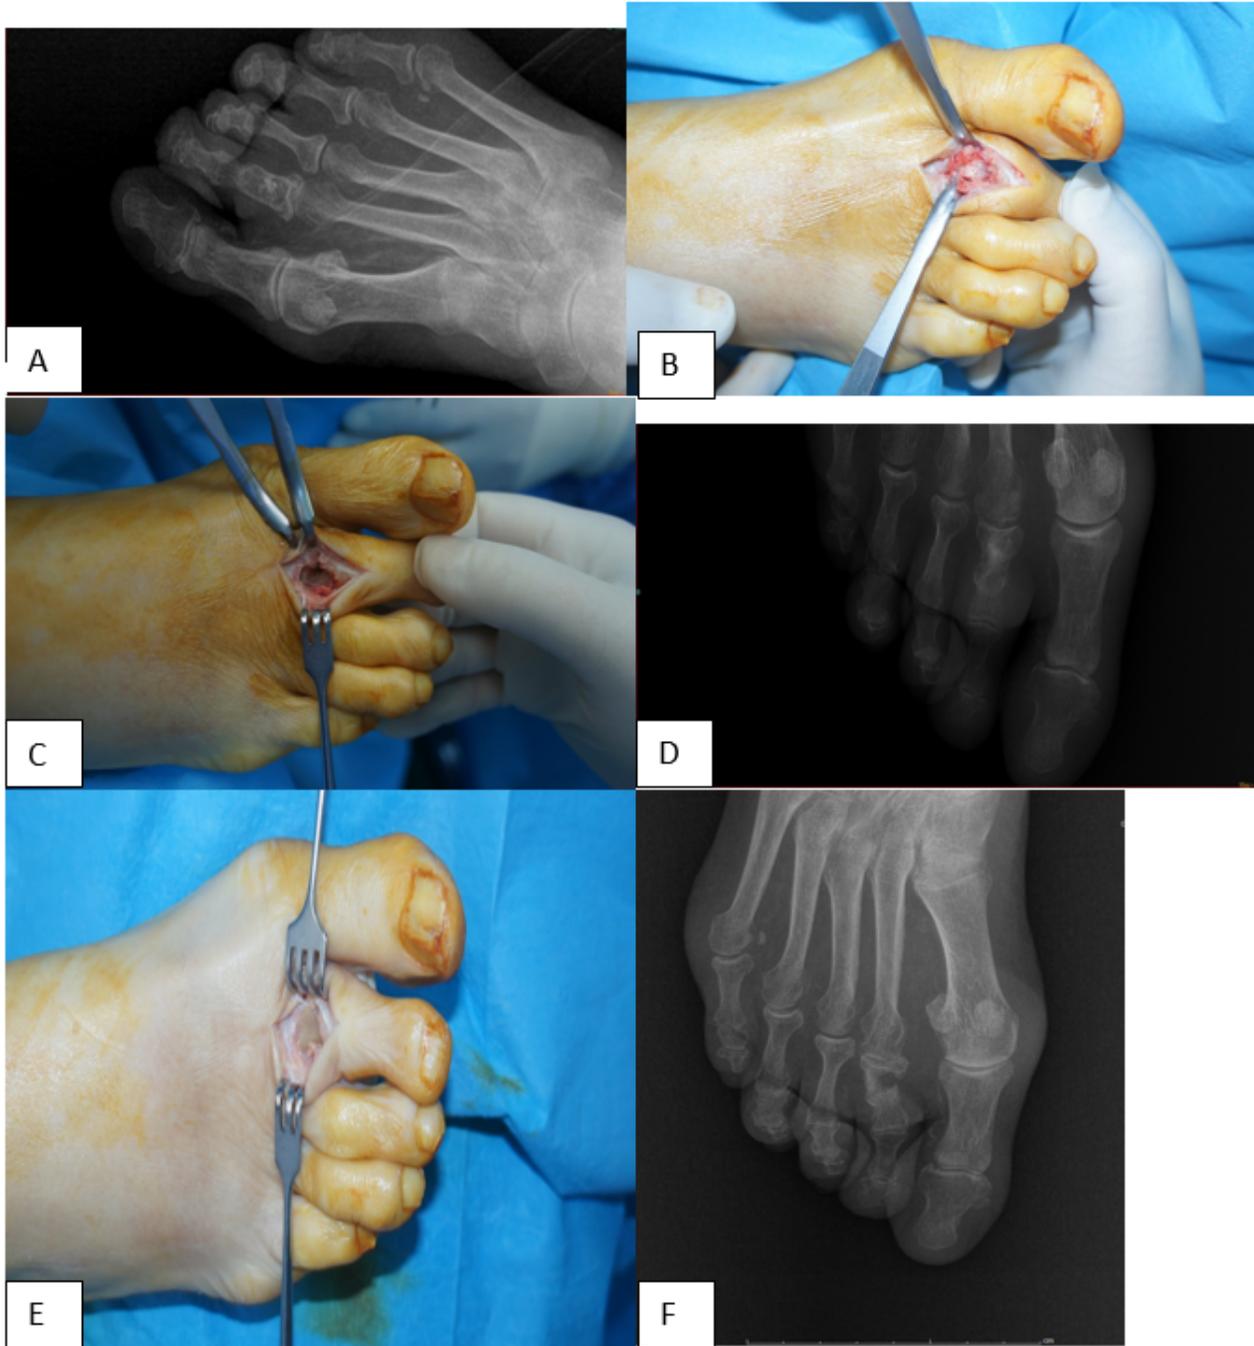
(A) LGCS at the second proximal phalanx. (B, C, and E) Intralesional curettage and pathological fracture. (D) Postoperative first day x-ray. (F) Fifth-month x-ray with nonunion.
